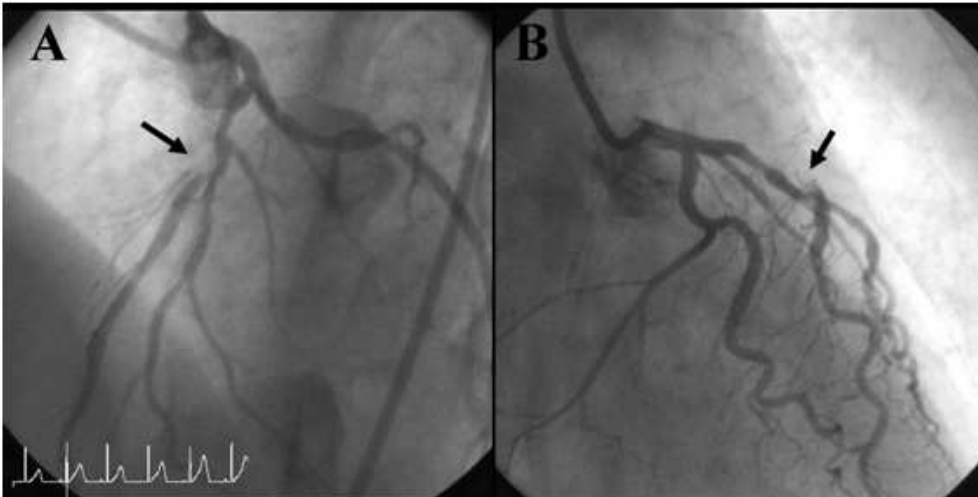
An coronary X-ray angiography of a patient with significant coronary occlusion. (A, B) The coronary angiography showed significant stenosis in mid-LAD (Image from [1]).
